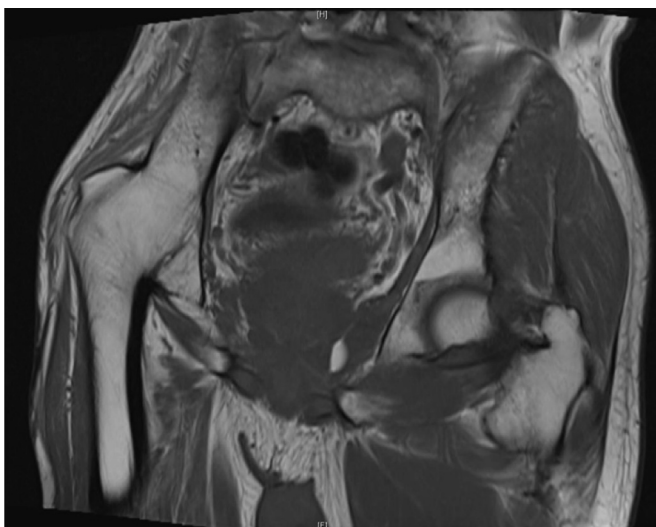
Magnetic resonance imaging demonstrating complete ankylosis as well as atrophy of the gluteus medius and subcutaneous fat.
